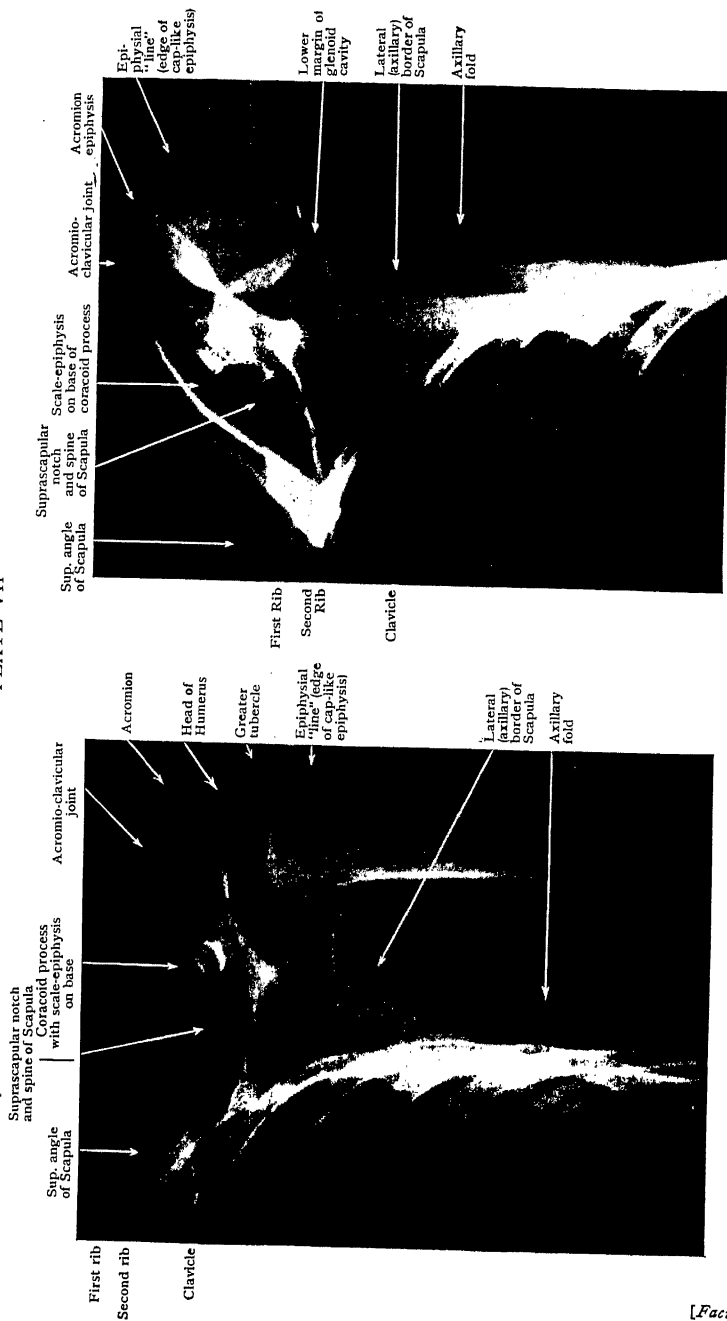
Radiograph of Shoulder of young man aged 18. Note the positions of Scapula and head of Humerus.
